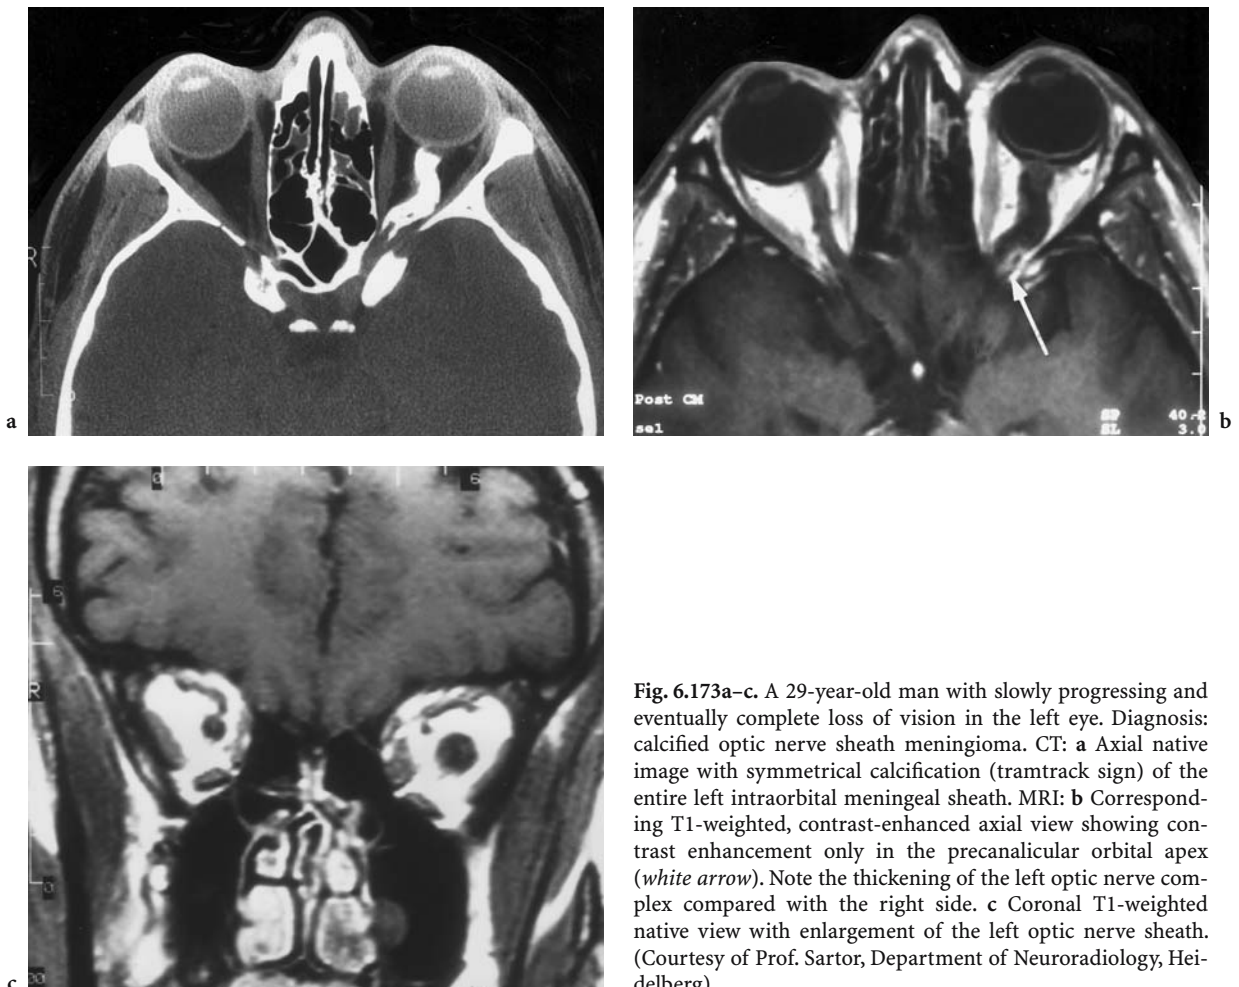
A 29-year-old man with slowly progressing and eventually complete loss of vision in the left eye. Diagnosis: calcified optic nerve sheath meningioma. CT: a Axial native image with symmetrical calcification (tram-track sign) of the entire left intraorbital meningeal sheath. MRI: b Corresponding T1-weighted, contrast-enhanced axial view showing contrast enhancement only in the precanicular orbital apex (*white arrow*). Note the thickening of the left optic nerve complex compared with the right side. c Coronal T1-weighted native view with enlargement of the left optic nerve sheath. (Courtesy of Prof. Sartor, Department of Neuroradiology, Heidelberg)
